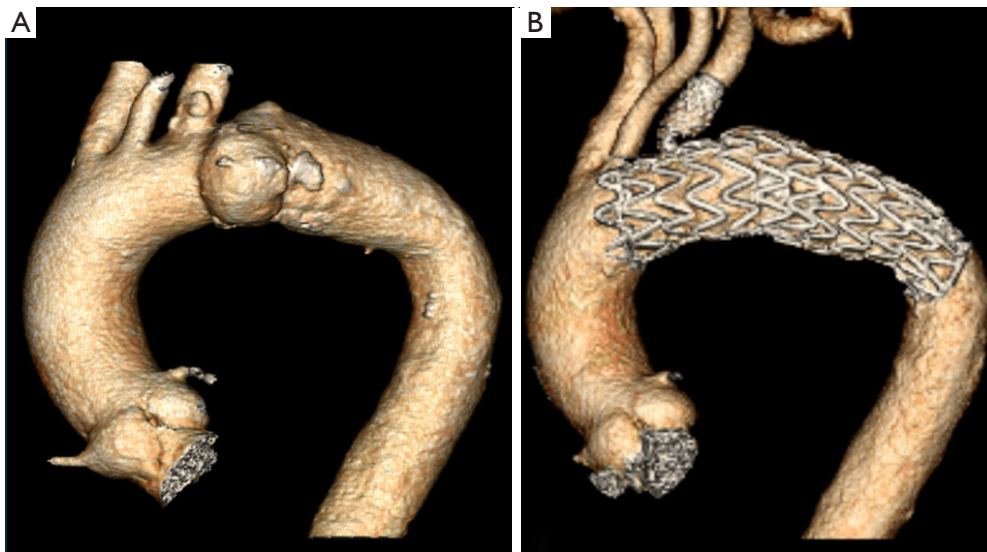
Three-dimensional reconstruction of pre- (A) and postoperative (B) CTA scan of a patient with a saccular distal aortic arch aneurysm treated with a single branched stent-graft (GORE TBE). CTA, computed tomography angiography.
